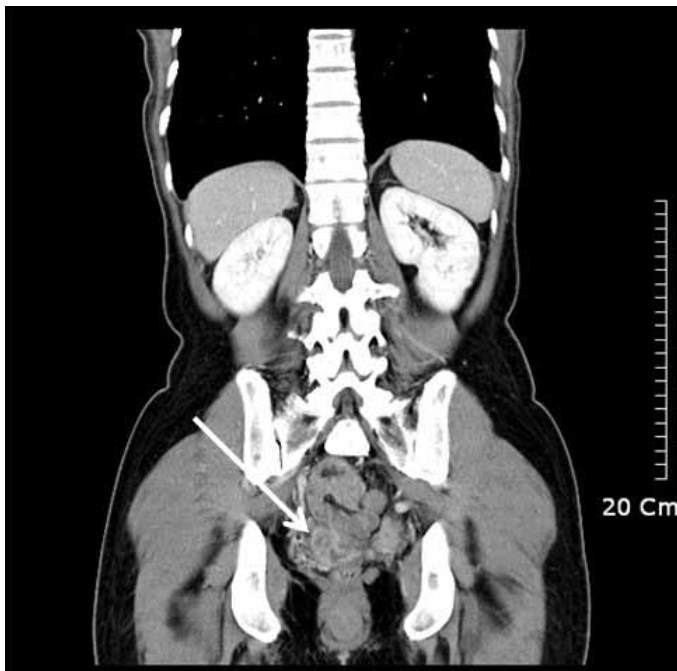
Initial computed tomography showed prominent both lateral ends of vaginal stump with irregular enhancement, especially right side (arrow). There was no hydronephrosis in both kidneys.
